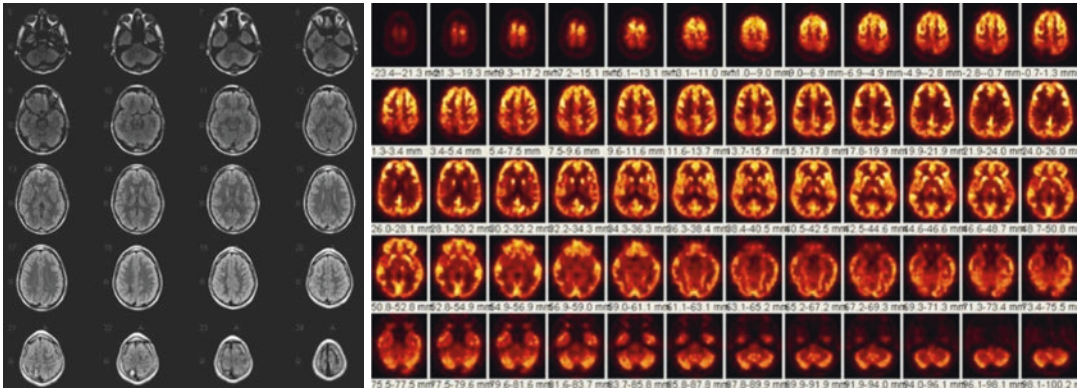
(Left) MRI scan sections of an 11-year-old boy suffering from seizure disorder since age 7. The patient has tonic–clonic seizures. The MRI scan shows an arterial venous malformation in the right parietal lobe.
